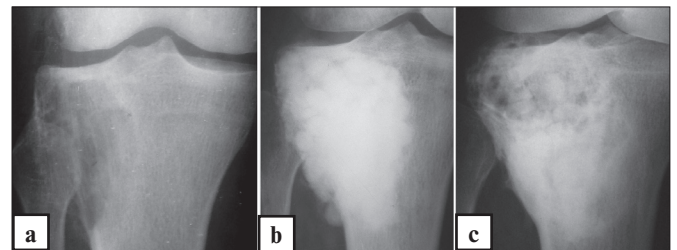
Patient, 57 years old. Giant cell tumor of the proximal tibia metaphysis, post intraosseous resection and bone defect plastic ceramic material. X-ray a) before surgery, b) 2 weeks after the operation, c) 12 months after the operation. There is a ceramic material alteration at the site of implantation.
